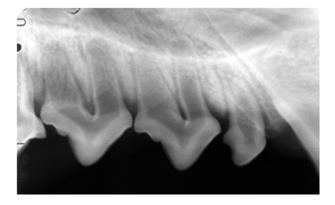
Preoperative radiograph showing open apices.
